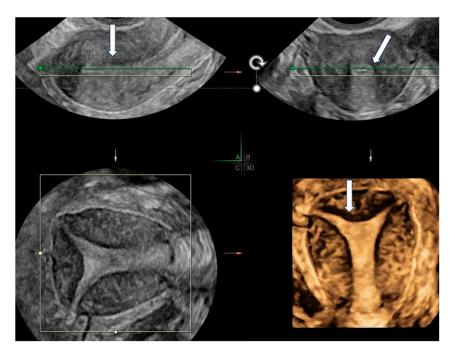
A 3D ultrasound image of the uterus in the multiplanar view.
